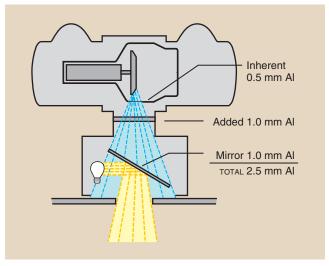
Total filtration consists of the inherent filtration of the x-ray tube, an added filter, and filtration achieved by the mirror of the light-localizing collimator.
